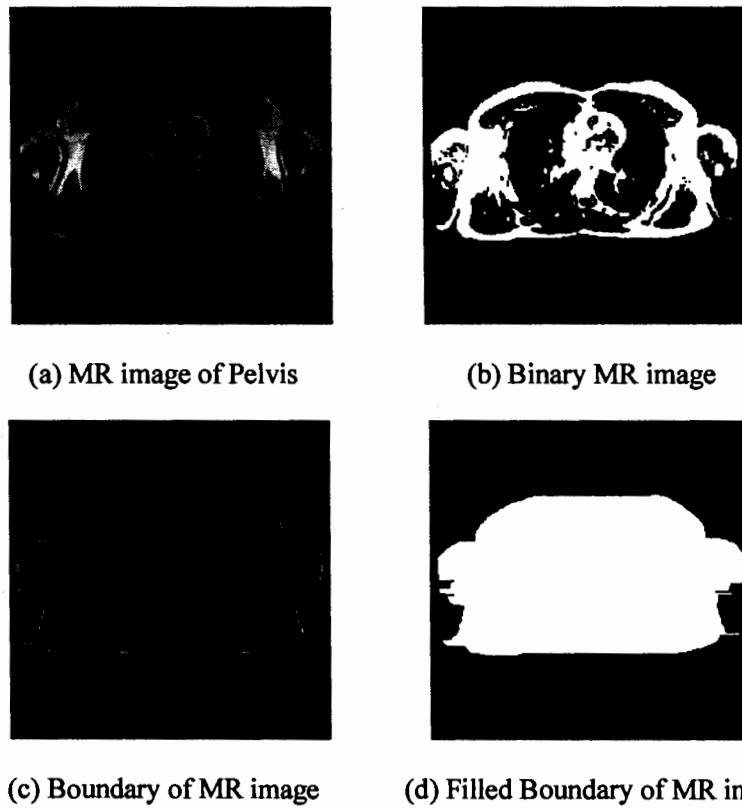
Steps to make foreground as a single region in MR image of Chest
